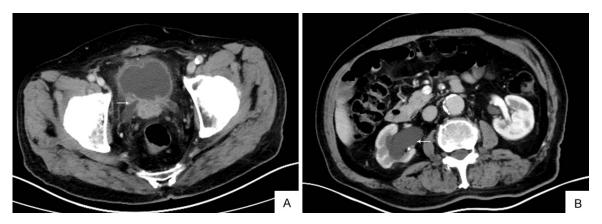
A. Computed tomography urography shows an irregular mass was located in the right posterior side of the bladder, which also shows an invasion of the bilateral ureters. B. The mass led to the dilatation of the proximal ureter and renal pelvis.
